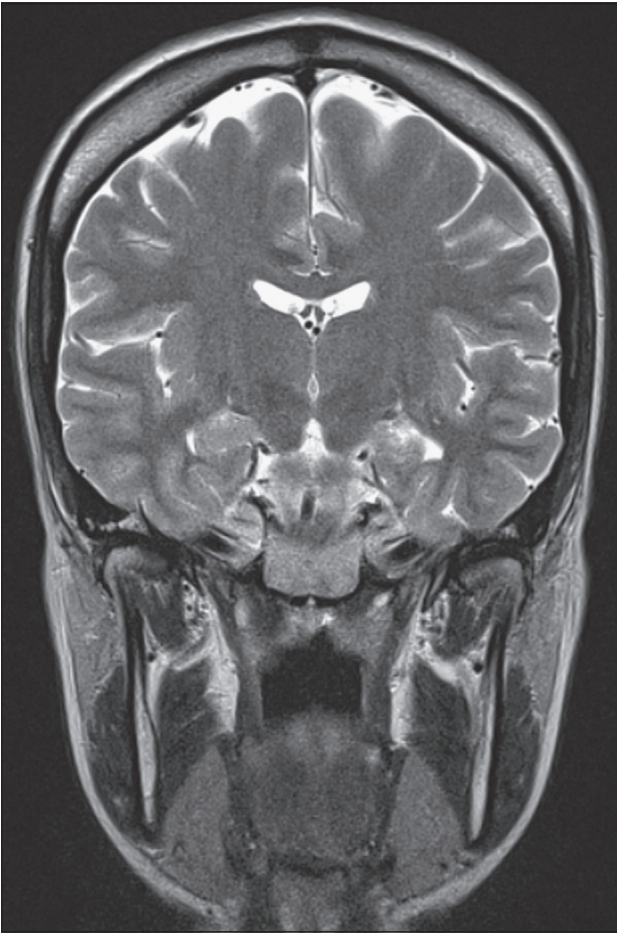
Coronal T2-weighted brain MRI (during follow-up) showing atrophy of both medial temporal lobes, mainly in the left hippocampus.
